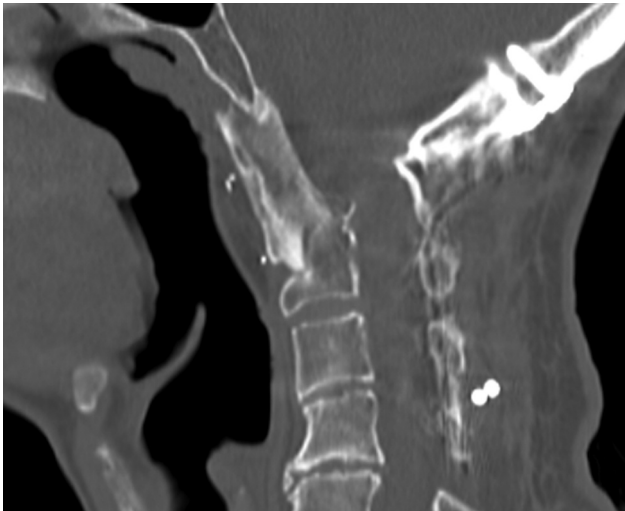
Computed tomography (CT) at 1 year postoperatively shows fusion between the grafted radius, iliac bone, and surrounding bone.
